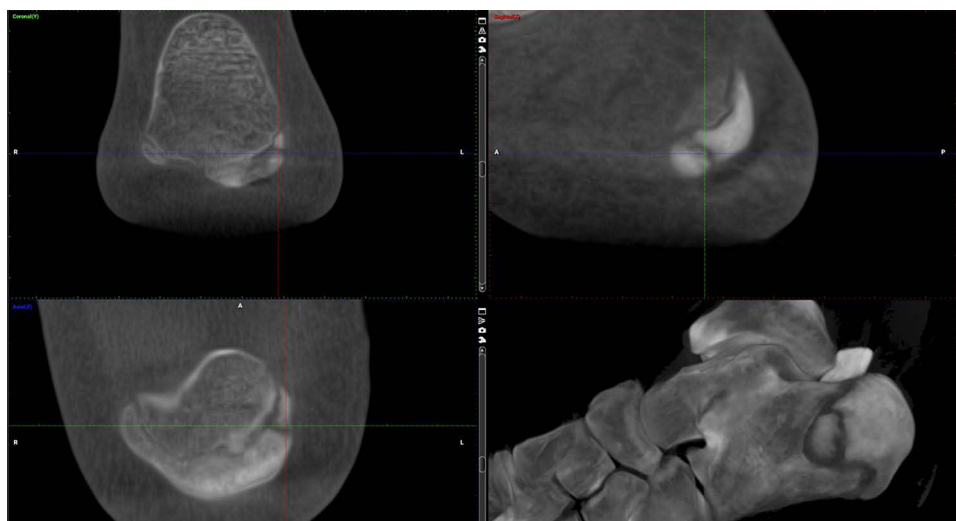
Weight-bearing cone beam CT (WBCT, SCS Med Series H22, 748mGy x cm²) showing a non-healed epiphyseal fracture of the calcaneus eight weeks after a landing in Parkour.
